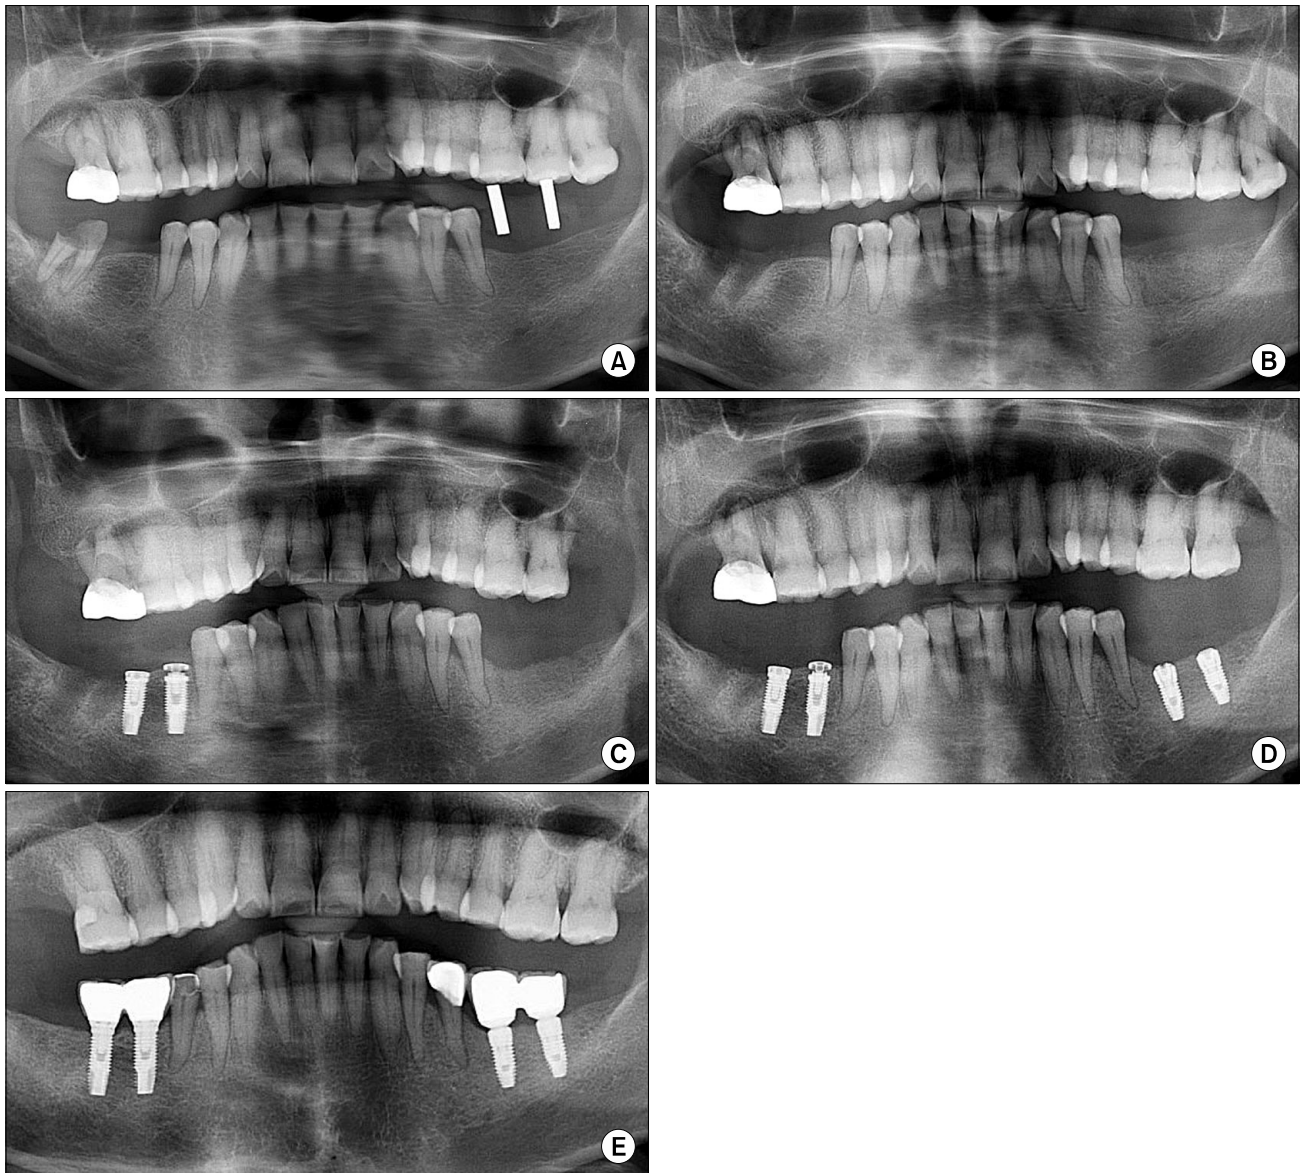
Radiographic images. (A) Preoperative panoramic radiograph. (B) Panoramic radiograph immediately after piezoelectric hinge-assisted ridge split procedure. (C) Postoperative panoramic radiograph after 3 months. (D) Panoramic radiograph after 4 months and implant installation. (E) Panoramic radiograph at 6 months in function.
